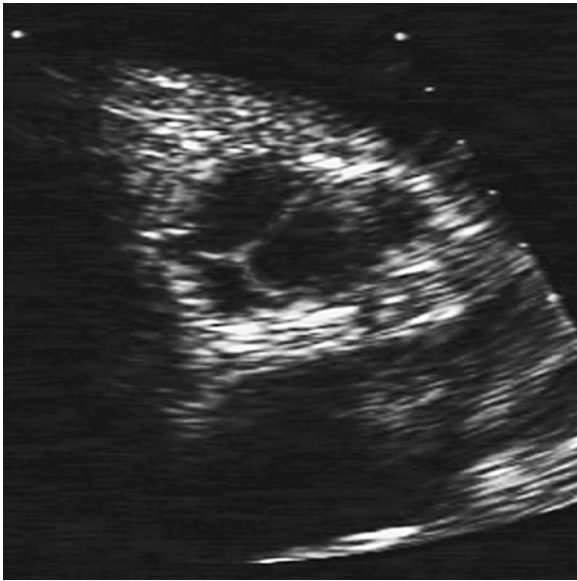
Short-axis echocardiogram of full root Freestyle valve. The aortic wall is slightly thicker than a native aorta.
